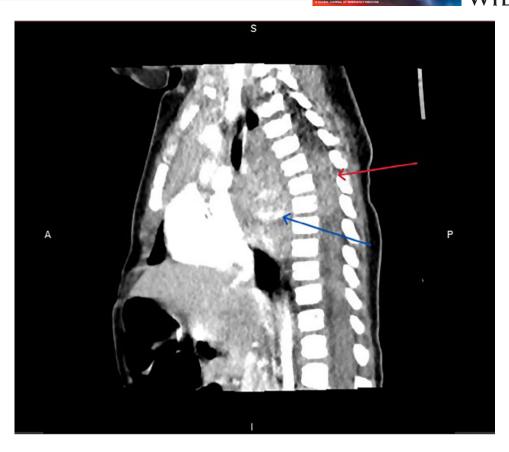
Computed tomography scan of chest (saggital view) shows neuroblastoma (blue arrow) and its intraspinal extension (red arrow).
